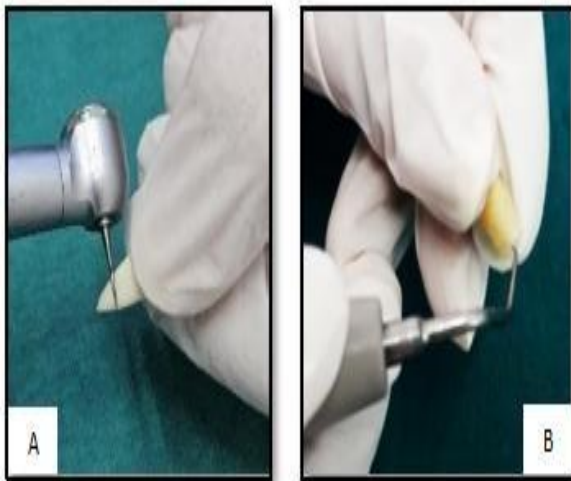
Root end resection and cavity preparation. A- 3mm of root end resection using Tapered fissure carbide bur, B- root end cavity preparation using ultrasonic
